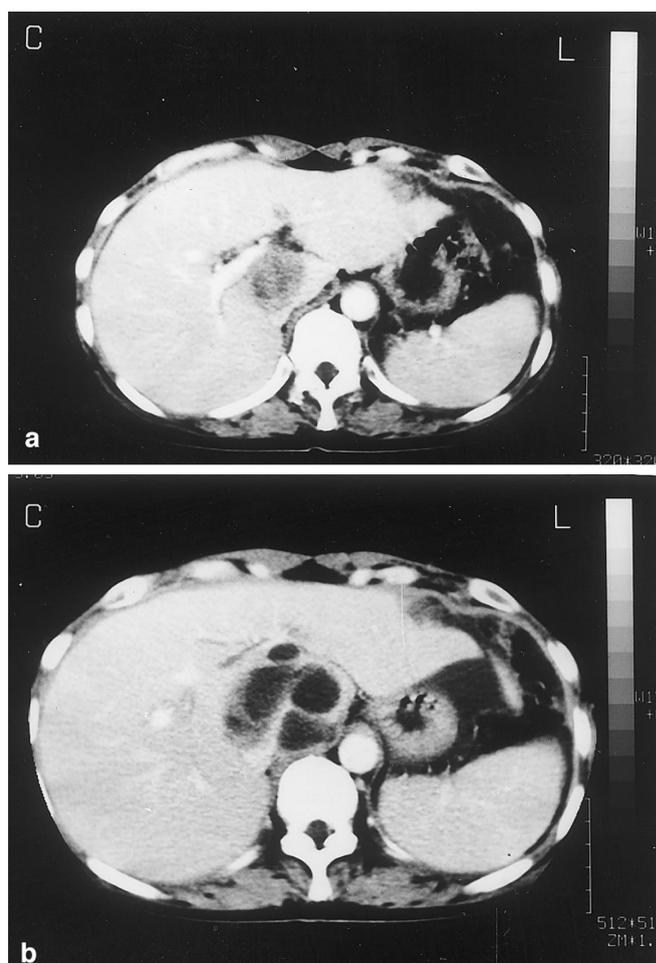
CT scan of the liver of patient 6 before (a) and after (b) treatment. This patient with ovarian cancer had multiple metastatic tumors in the liver (a). After treatment the density of the tumor remarkably decreased in CT scan (b). The lysis of these tumors was obvious
